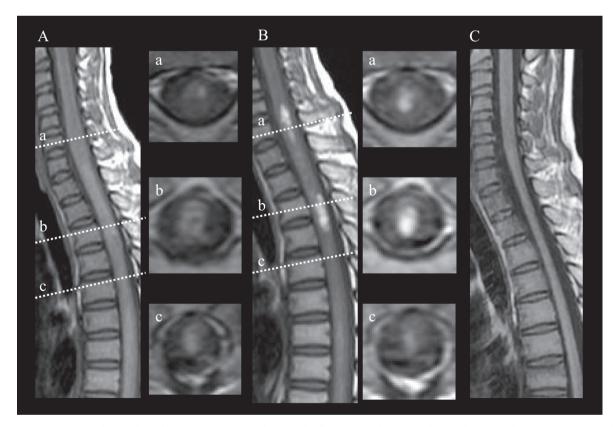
Serial MR images of T1-weighted images. A: At admission, longitudinally extensive cord lesions mainly involving the gray matter with mild hyperintensity (a–c). B: On day 20, very high intensity lesions showing expanding hemorrhagic lesions (a, b). C: 6 months later after the onset, no signal changes and mild atrophy.
